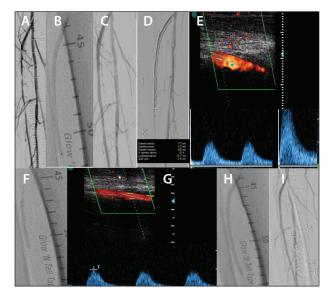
Ultrasound guidance of tibial angioplasty. Long tandem stenosis in the proximal anterior tibial artery segment (A) treated with a 3- X 80-mm balloon (B) with a good angiographic result (C, D) but a significant residual gradient on duplex evaluation (E), which disappeared after use of a 3- X 40-mm noncompliant balloon inflated to 22 atm (F, G). Final dilatation with a 3- X 80-mm DCB with an optimal result (H, I).
